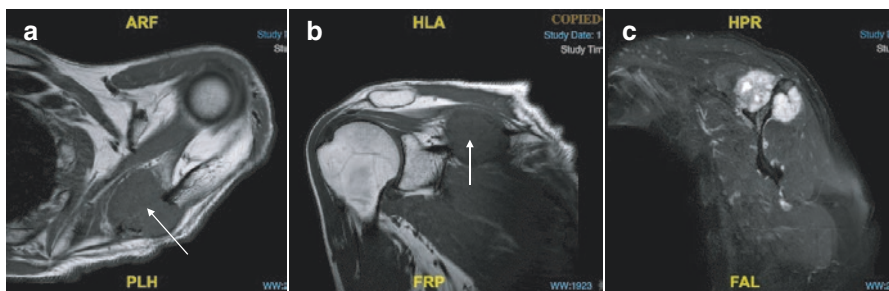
T1-weighted, (a) axial, (b) coronal and (c) sagittal T2 fat-suppressed MRI images demonstrating high-grade chondrosarcoma (arrow) of the supraspinatus fossa and spine of the scapula. Resection will include part of the supraspinatus and infraspinatus muscles
